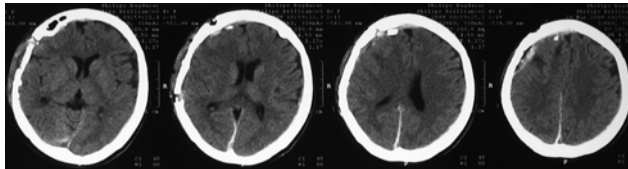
Postoperative CT-scan 7 days after surgery
